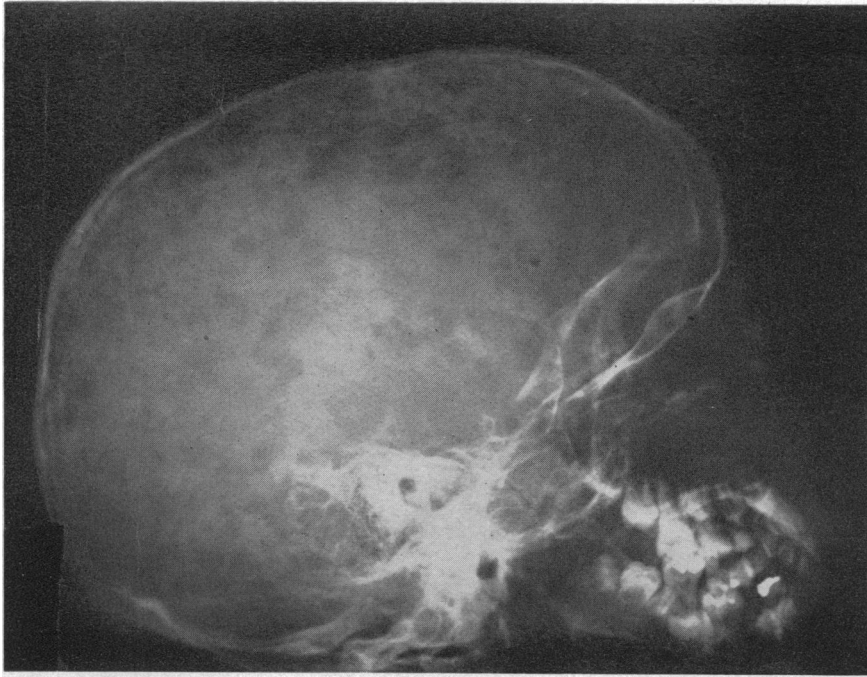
Radiograph of skull, showing extensive round translucent areas.
